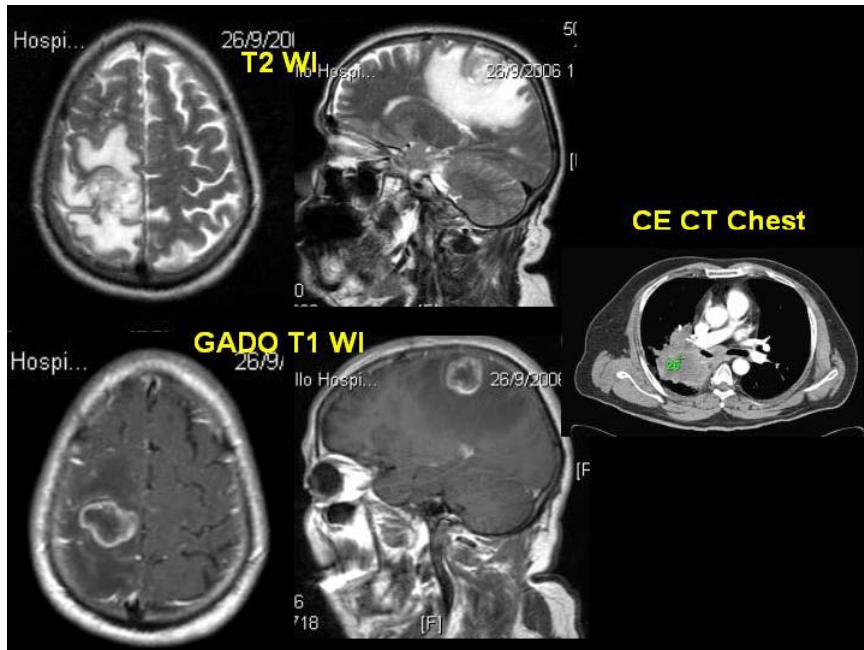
MRI shows a thick walled peripheral enhancing nodular lesion with area of necrosis and marked peri-enhancing edema in the right parietal lobe; CT chest reveals central bronchogenic carcinoma
